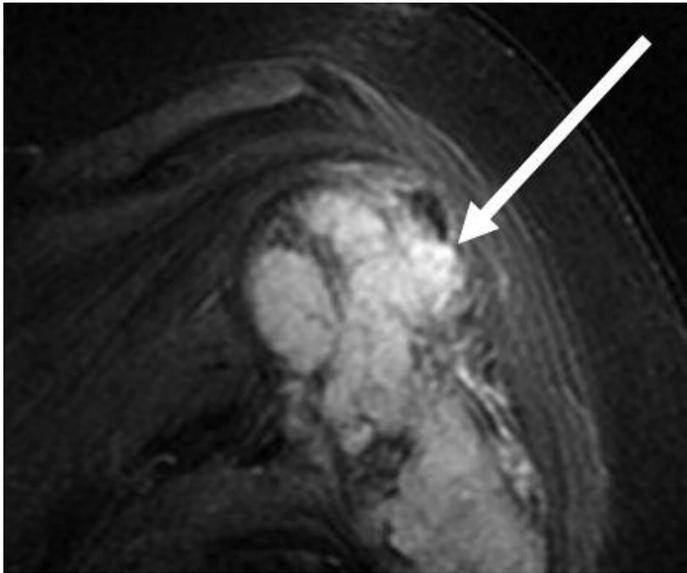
Left humerus metastasis on MRI left upper extremity at presentation- Case 2
